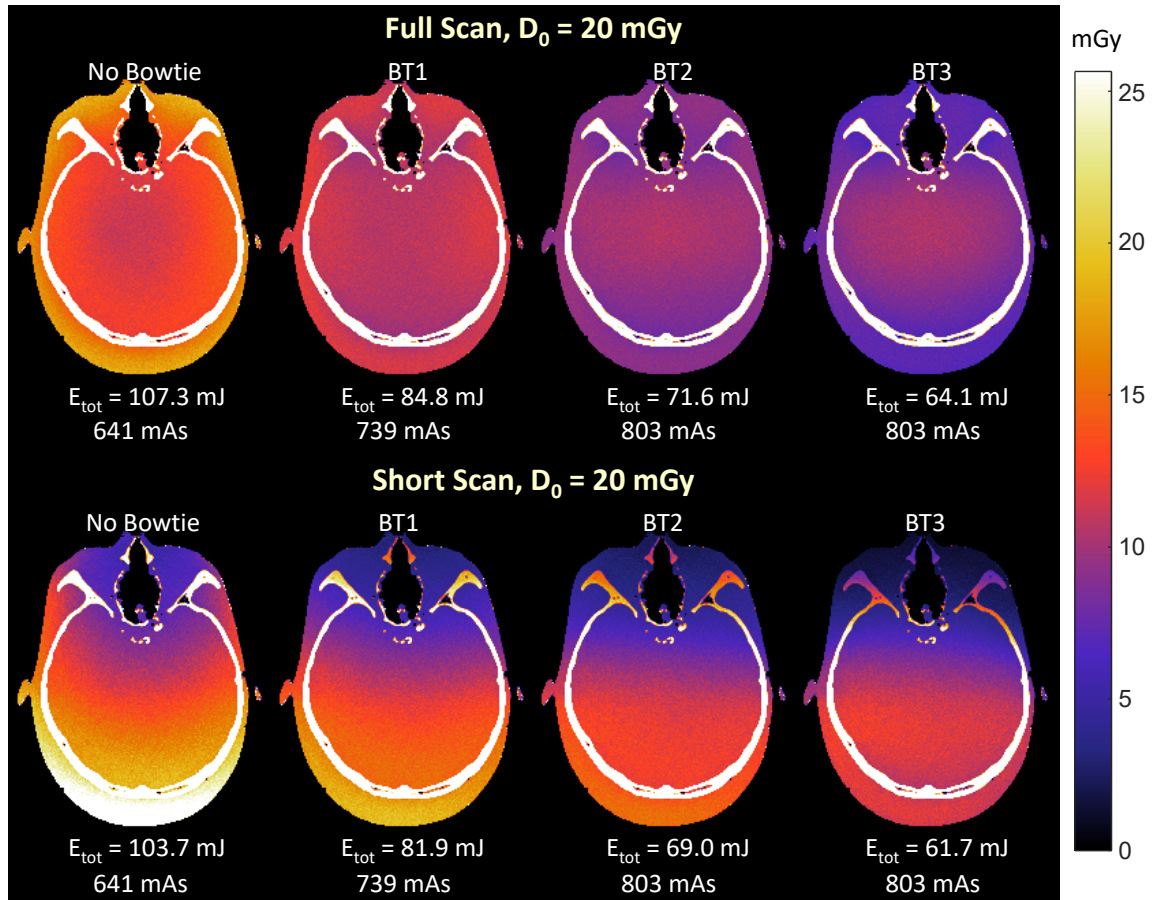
Monte carlo dose calculations for full and half scan CBCT acquisition with three bowtie designs (BT1, BT2, and BT3 as in Figure 5.1). Bowtie filters are seen to reduce peripheral dose and total energy imparted ( $E_{tot}$ ). Combination with a short scan trajectory further reduces  $E_{tot}$  and, especially, the anterior dose (i.e., dose to the eye lens).
